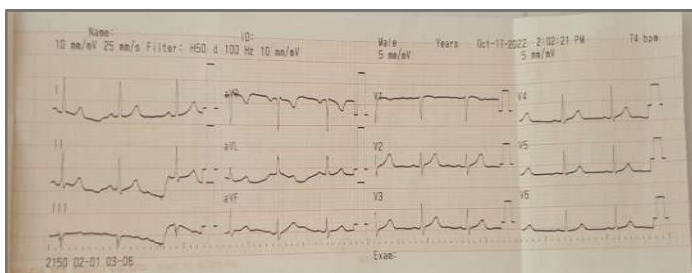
The preoperative echocardiography of patient
